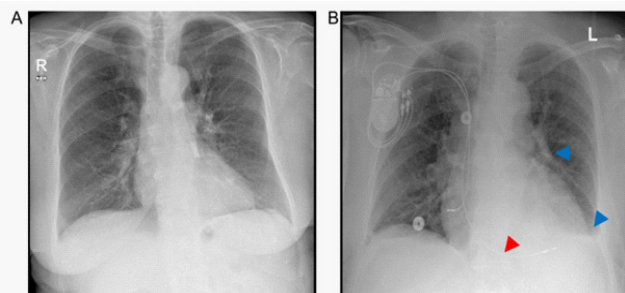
Postoperative chest X-ray two days after two-chamber pacemaker-upgrade with a LV-lead instead of a RV-lead. Blue arrow: Position of sinus coronarius-lead showed no need for left-ventricular position for adequate pacing with excellent pacemaker values.
